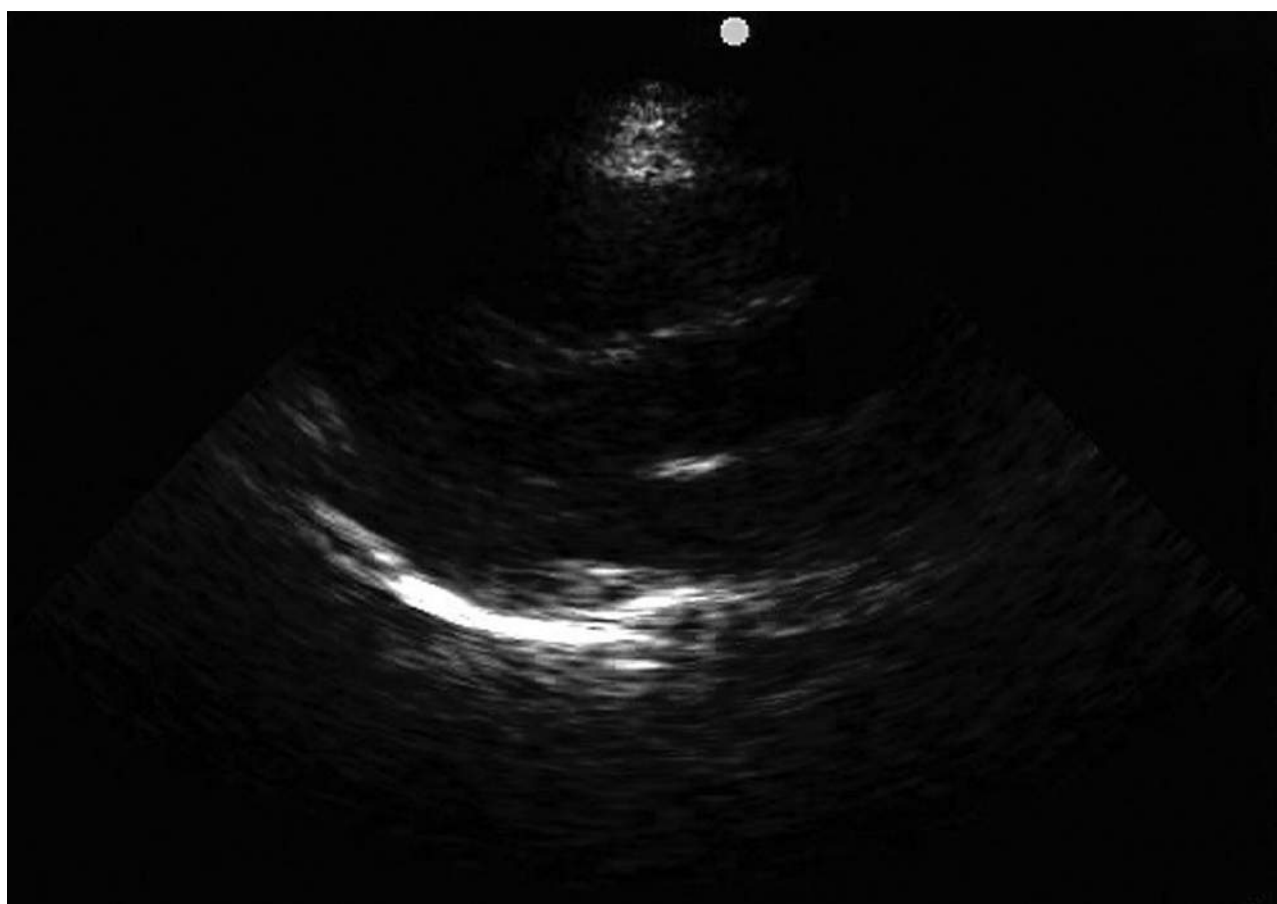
Parasternal long-axis view showing right ventricular dilation. Note that the right ventricle measures > 3 cm in this view. Septal flattening and bowing of the septum to the left is also seen.
